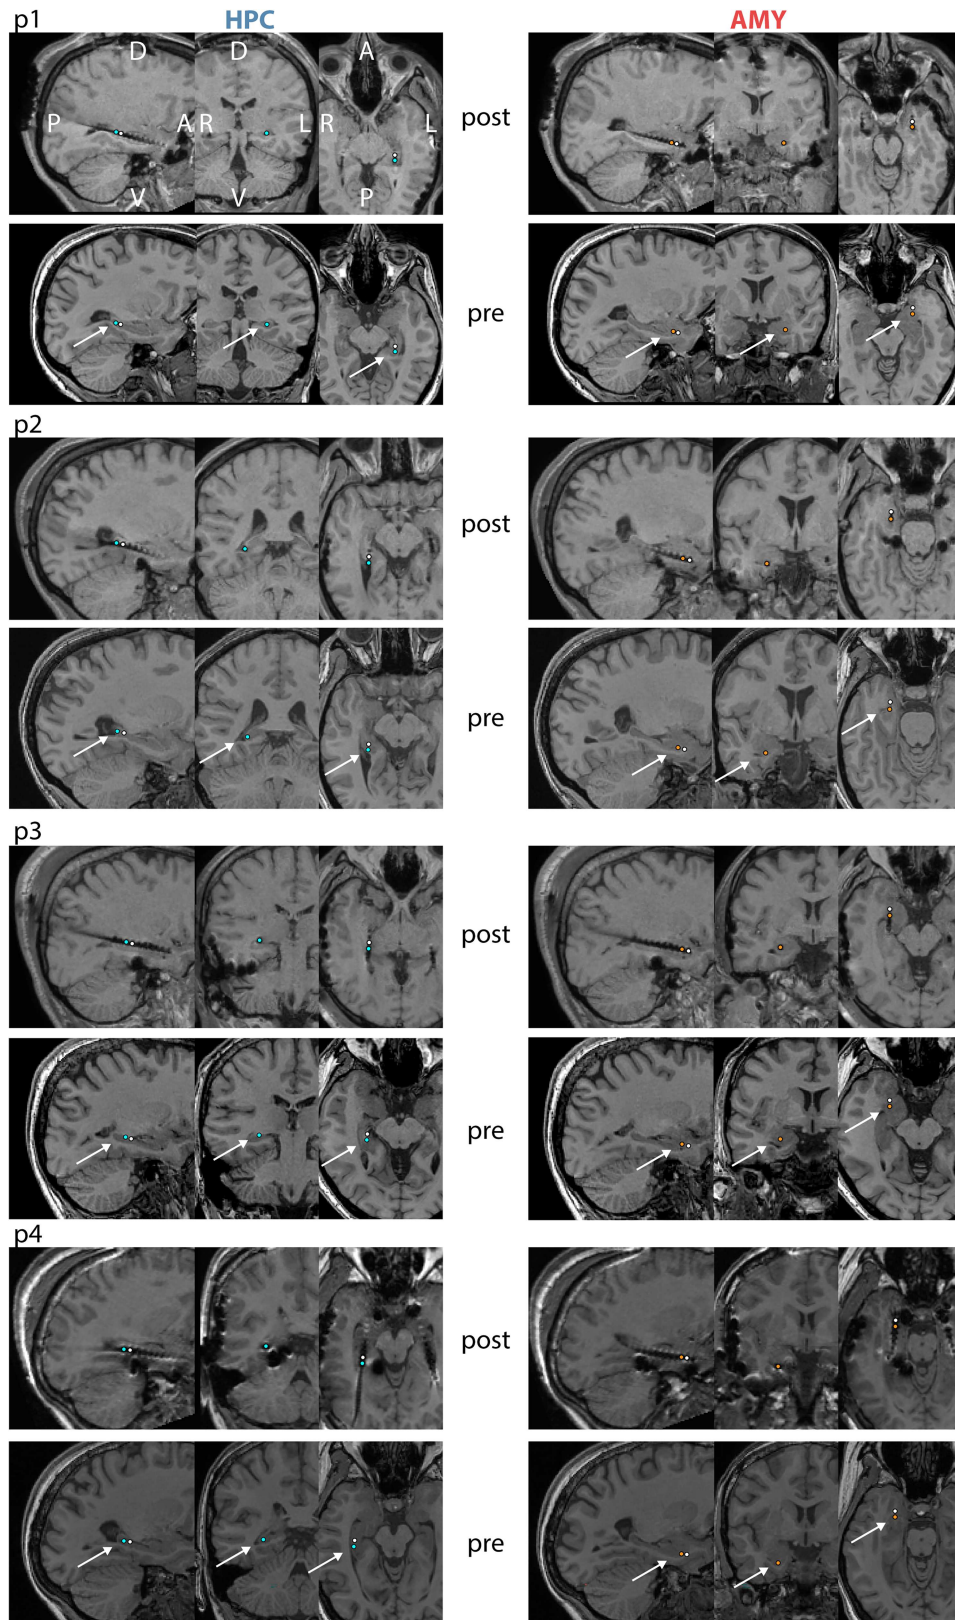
Electrode locations for individual patients. For each patient, top and bottom panels show co-registered post- and preimplantation T1-weighted MRI scans, respectively. Selected HPC contacts are indicated in left panels (blue: active, white: reference) and selected AMY contacts are shown in right panels (orange: active, white: reference). A: anterior, P: posterior, D: dorsal, V: ventral, L: left, R: right.
